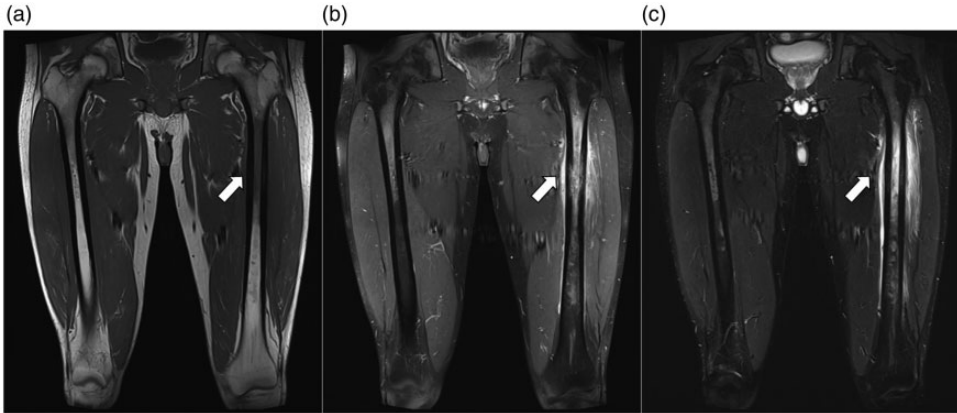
Magnetic resonance imaging of the left thigh showed (a) slightly low to intermediate signal intensity on T1-weighted imaging, (b) enhancement of the periosteum and adjacent soft tissue on gadolinium contrast-enhanced T1-weighted imaging, and (c) very high signal intensity on T2-weighted imaging at the left femoral shaft.
